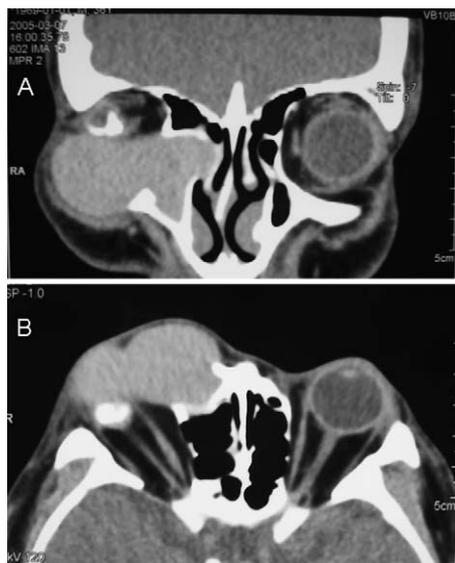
A CT scan revealed a dumbbell-shaped cyst that was situated anterior to the globe and extended into the right ethmoidal sinus (A). All extraocular muscles and the optic nerve were found to be present. A calcified mass was identified within the right microphthalmic eye (B).
